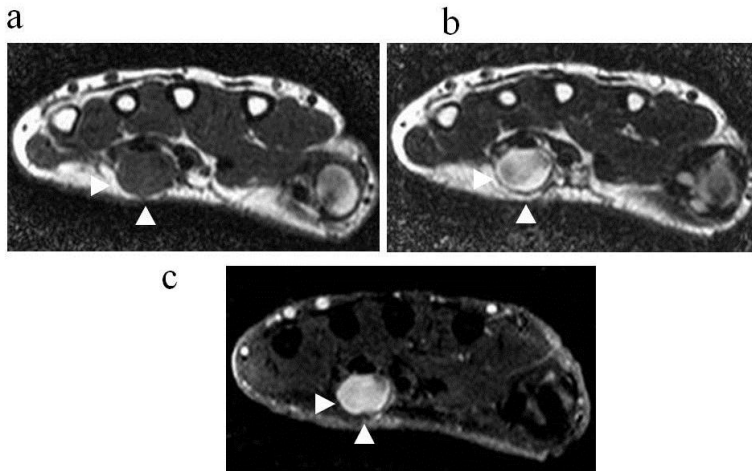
Magnetic Resonance Image of the hand
